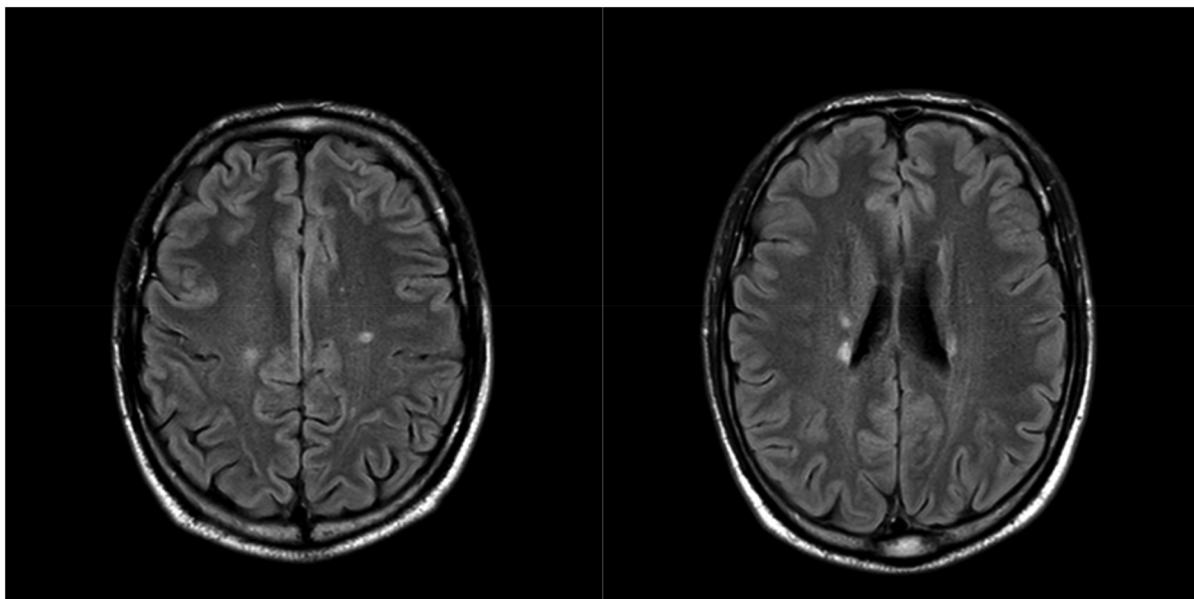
T2 FLAIR sequence showing periventricular and callosal lesions which are disseminated in space.
